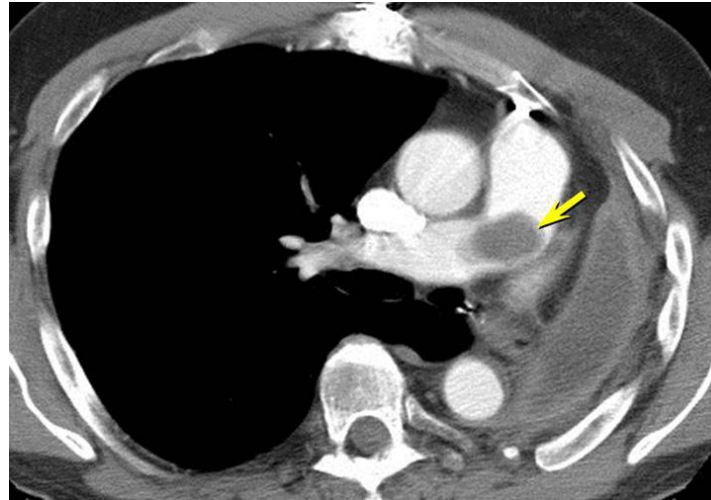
Axial enhanced thoracic CT through the level of the main and right pulmonary artery 10 months following left pneumonectomy shows a new soft tissue filling defect within the main and proximal right pulmonary artery (arrow), representing tumor recurrence.
